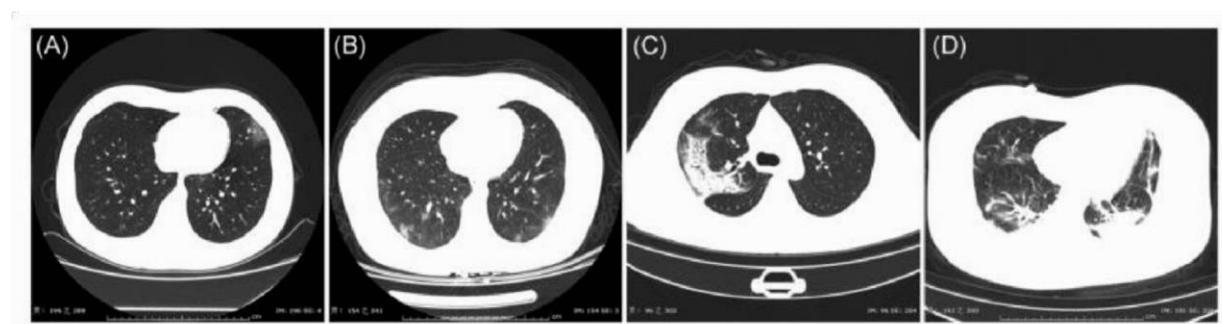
[230] Chest CT Manifestations of COVID-19. A, Single GGO; B, diffuse GGO; C, consolidation; D, both GGO and consolidation. COVID-19, coronavirus disease 2019; CT, computed tomography; GGO, ground-glass opacities
